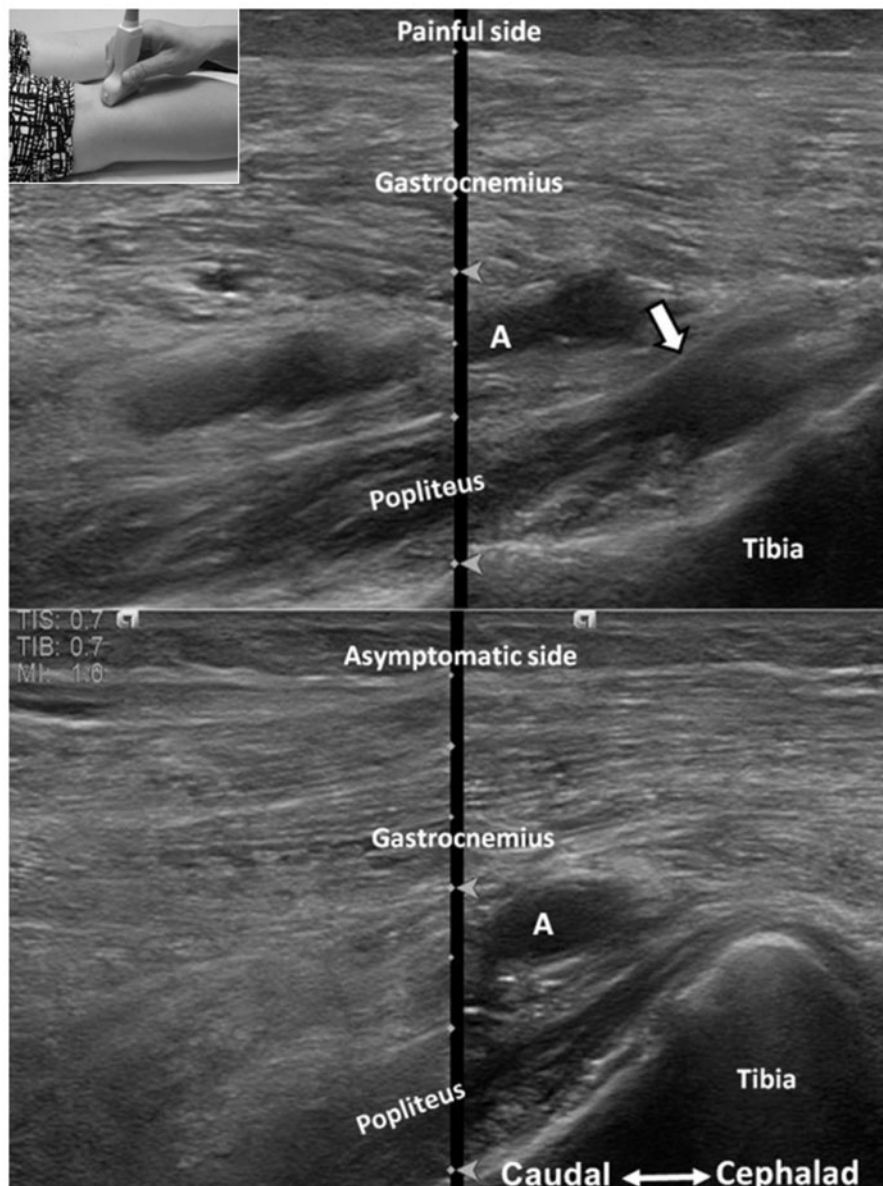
Ultrasound image (long-axis split screen view) shows the popliteus muscle coursing between the posterior tibia and the popliteal neurovascular bundle. At the asymptomatic side, the muscle has a fibrillar echotexture; however, it appears hypoechoic with focal swelling (arrow) at the painful side. A = popliteal artery. The insert at the upper-left side of the figure indicates probe positioning.
